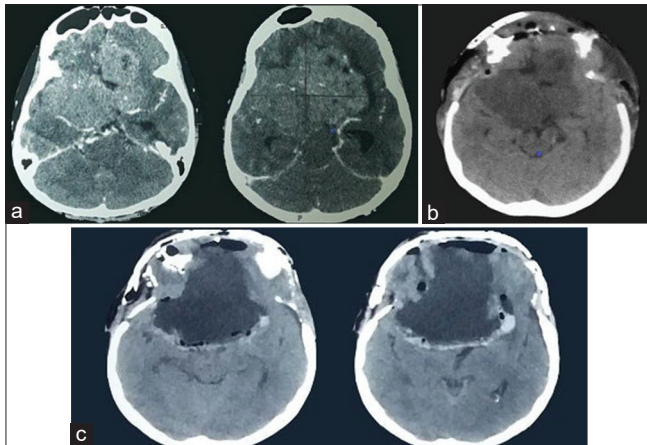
Computed tomography scan of a 44-year-old female diagnosed with meningioma of tuberculum sellae suffering consciousness decrease. (a) Contrast computed tomography scan of the head showing hyperdense lesion which was homogeneously enhanced. The lesion occupying the anterior and middle cranial base was spreading bilaterally and obliterating the basal cistern which indicates severe brain edema. (b) A noncontrast head computed tomography, 3 days after bifrontal decompressive craniectomy, brain edema was released seen from the re-opening of the cistern. (c) Head computed tomography scan 3 weeks after tumor resection surgery and cranioplasty, there were no signs of intracranial pressure increase
